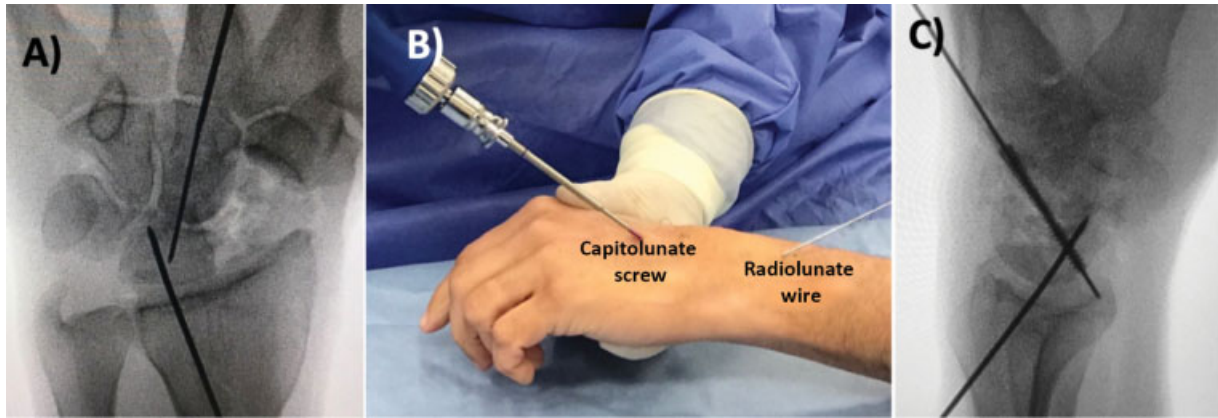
Fixation of the capitulate screw. (A) Intraoperative anteroposterior radiography of the wrist. Note the capitulate wire and the drill. (B) Capitulate screw insertion. (C) Intraoperative lateral radiography of the wrist, showing the capitulate screw.
